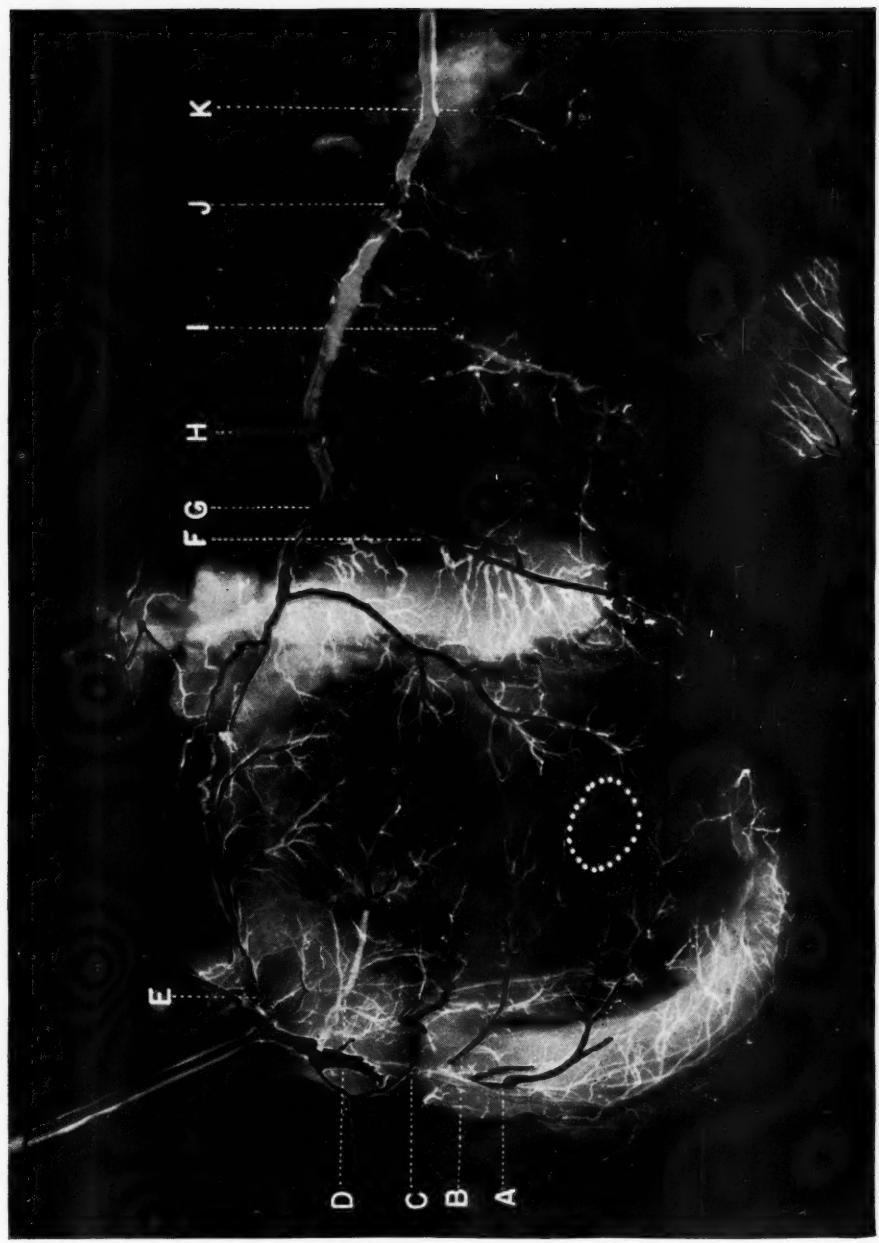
Colored photograph of roentgenogram of injected diseased heart. Detailed clinical and pathologic data of this case appear in Case IV. Reproduced with permission of the publishers, The C. V. Mosby Company, from the *Am. Heart J.*, 19: 5, 1940.²⁰
